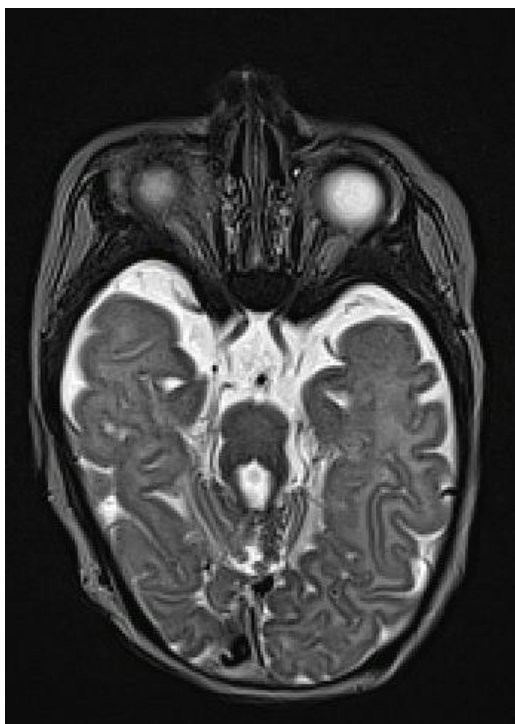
Axial brain MRI with features of JS: thickened, excessively horizontally positioned superior cerebellar peduncles (MTS), hypoplastic and dysplastic cerebellar vermis (Patient II).
